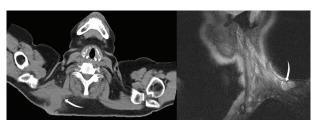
(Left Image) The arrow shows the tumor infiltrating the trapezius muscle (CT scan) (Right image) The arrow points the 2 subcutaneous nodules at the posterolateral site of the neck on the MRI
